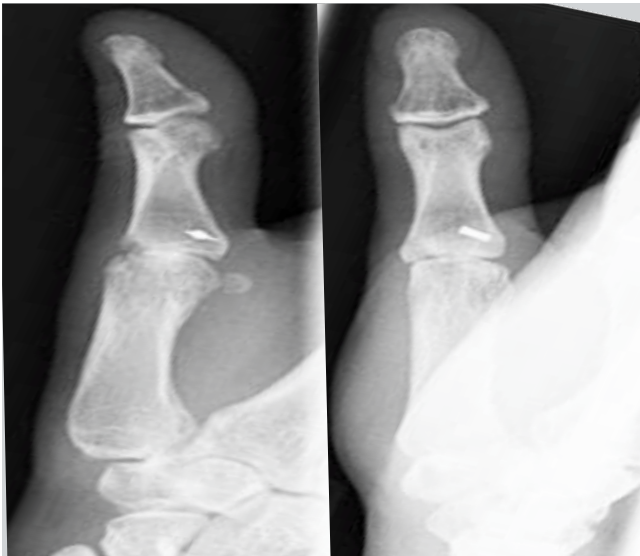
AP and lateral radiographs 12 months after the injury showing good reduction
